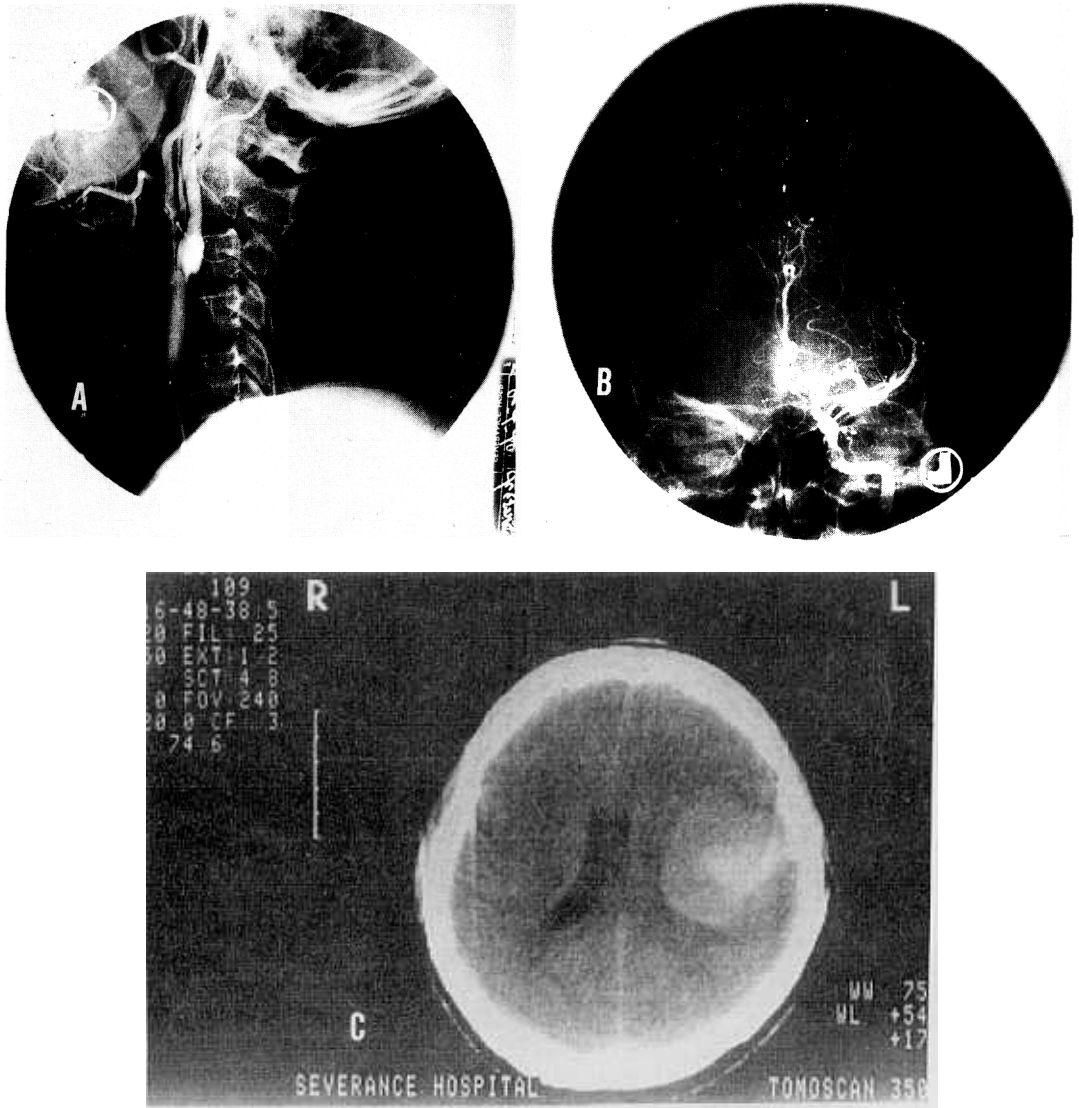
Angiographic and CT findings of patient 17.
